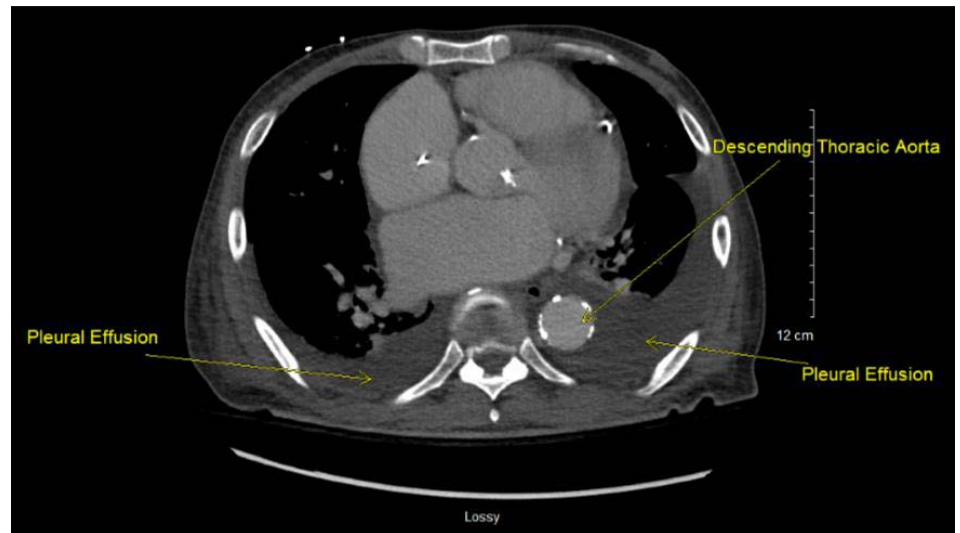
CT Chest with Contrast: Descending Thoracic Aorta
